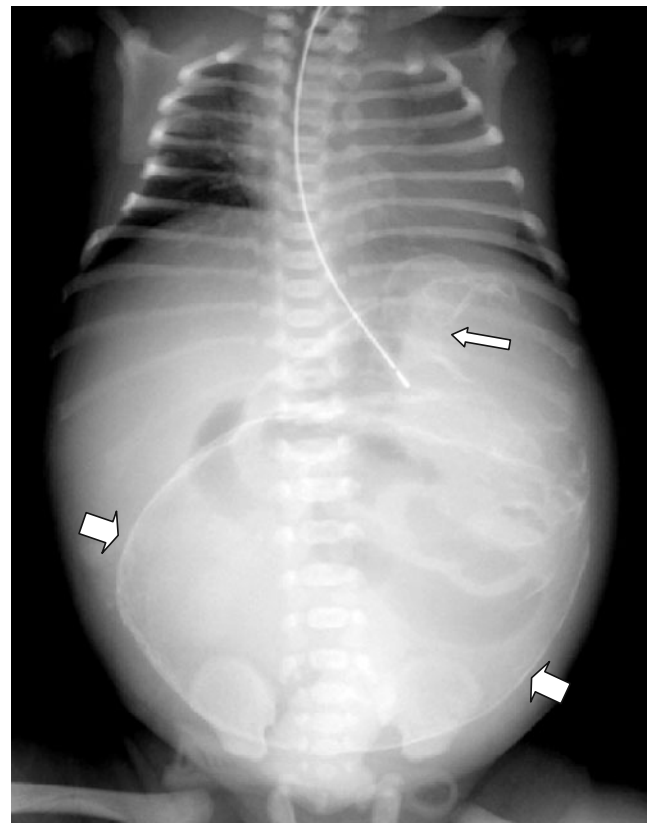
Supine radiograph of the chest and abdomen
